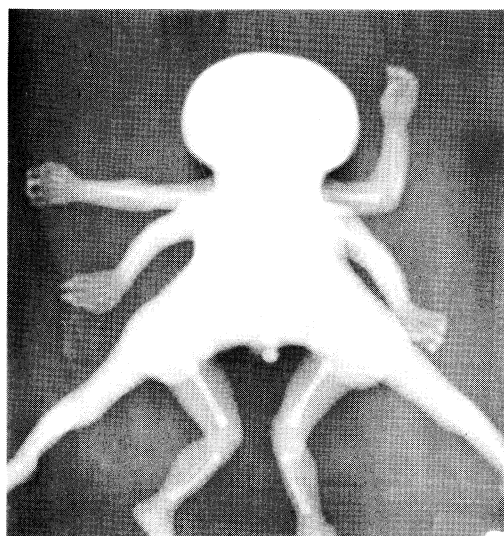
Post mortem total body roentgenogram of conjoined cephalothoracopagus twins, anteroposterior view. Note the common head with two spines extension laterally, the fusion of the chest and abdomen and the four upper and lower extremities.
